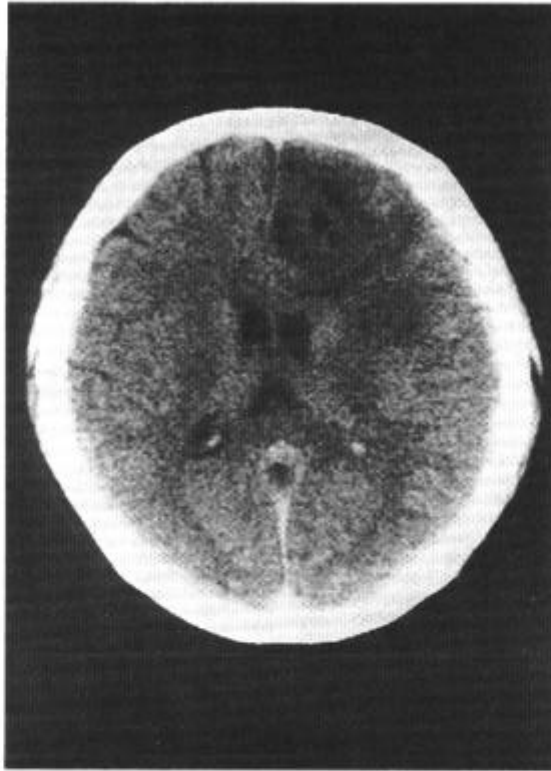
A CT scan of case 7 revealed a low density lesion in the right frontal region.
